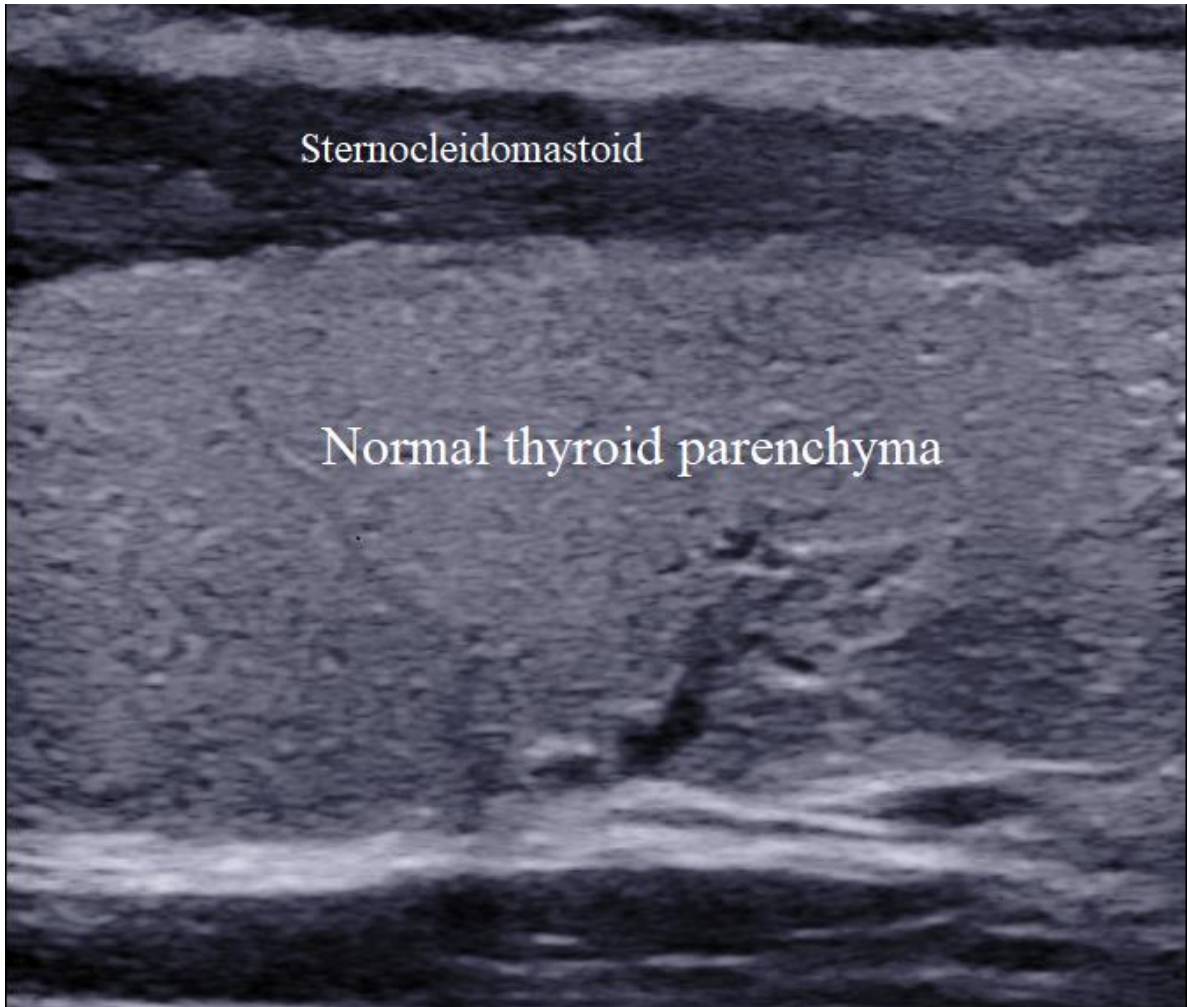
3 A longitudinal grey scale ultrasound scan of a normal right lobe of the thyroid gland.
